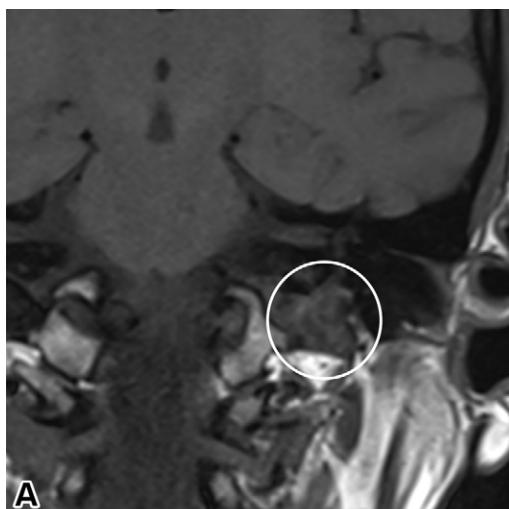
Paraganglioma of the jugular bulb in a 61-year-old patient with left-sided pulsatile tinnitus and normal hearing. An MRI study of the IAC was interpreted as normal. (A, B) Coronal precontrast (A) and postcontrast (B) T1-weighted images show a T1-hypointense lesion (circle in A) near the jugular foramen with avid postcontrast enhancement (circle in B). The patient presented for angiography. (C) Frontal DSA image obtained with selective external carotid artery injection shows avid enhancement (circle) corresponding to the enhancing mass at MRI, with arterial supply from the ascending pharyngeal and occipital arteries. (D) Copper 64 tetraazacyclododecane tetraacetic acid-octreotate (DOTATATE) staging scan shows the same lesion (arrow) but no other lesions. The remainder of the scan shows normal physiologic uptake of DOTATATE in the pituitary gland, salivary glands, thyroid gland, liver, spleen, kidneys, and bowel. The patient opted for conservative management with routine surveillance imaging.
